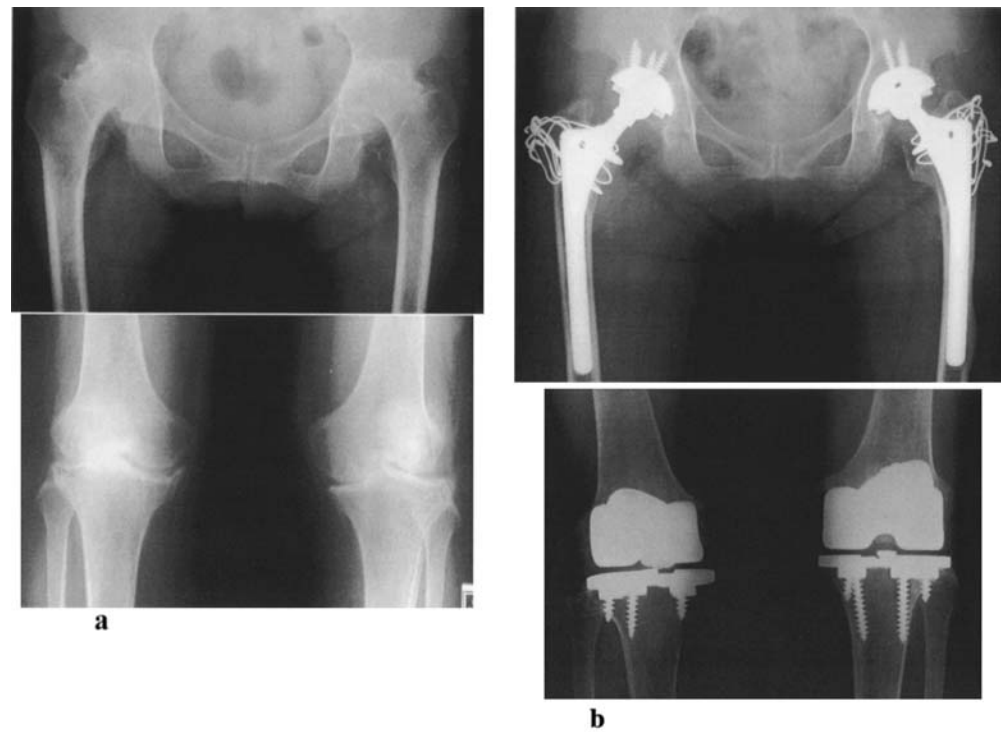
Case 1. a The X-ray finding prior to the first surgery. Marked destruction of the bilateral hip and bilateral knee joints was observed. b Right total hip arthroplasty (THA) using HGP2 and right total knee arthroplasty (TKA) using MG2 were simultaneously performed; left
